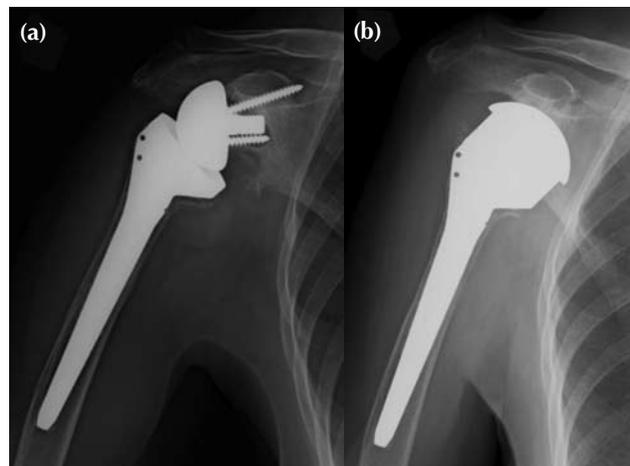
Radiographs showing (a) severe glenoid notching (Nerot grade 4) with loosening of the glenoid component 5 years after implantation of the Delta 3 prosthesis, and (b) conversion to a hemiarthroplasty owing to the loss of bone stock in the scapular neck.
